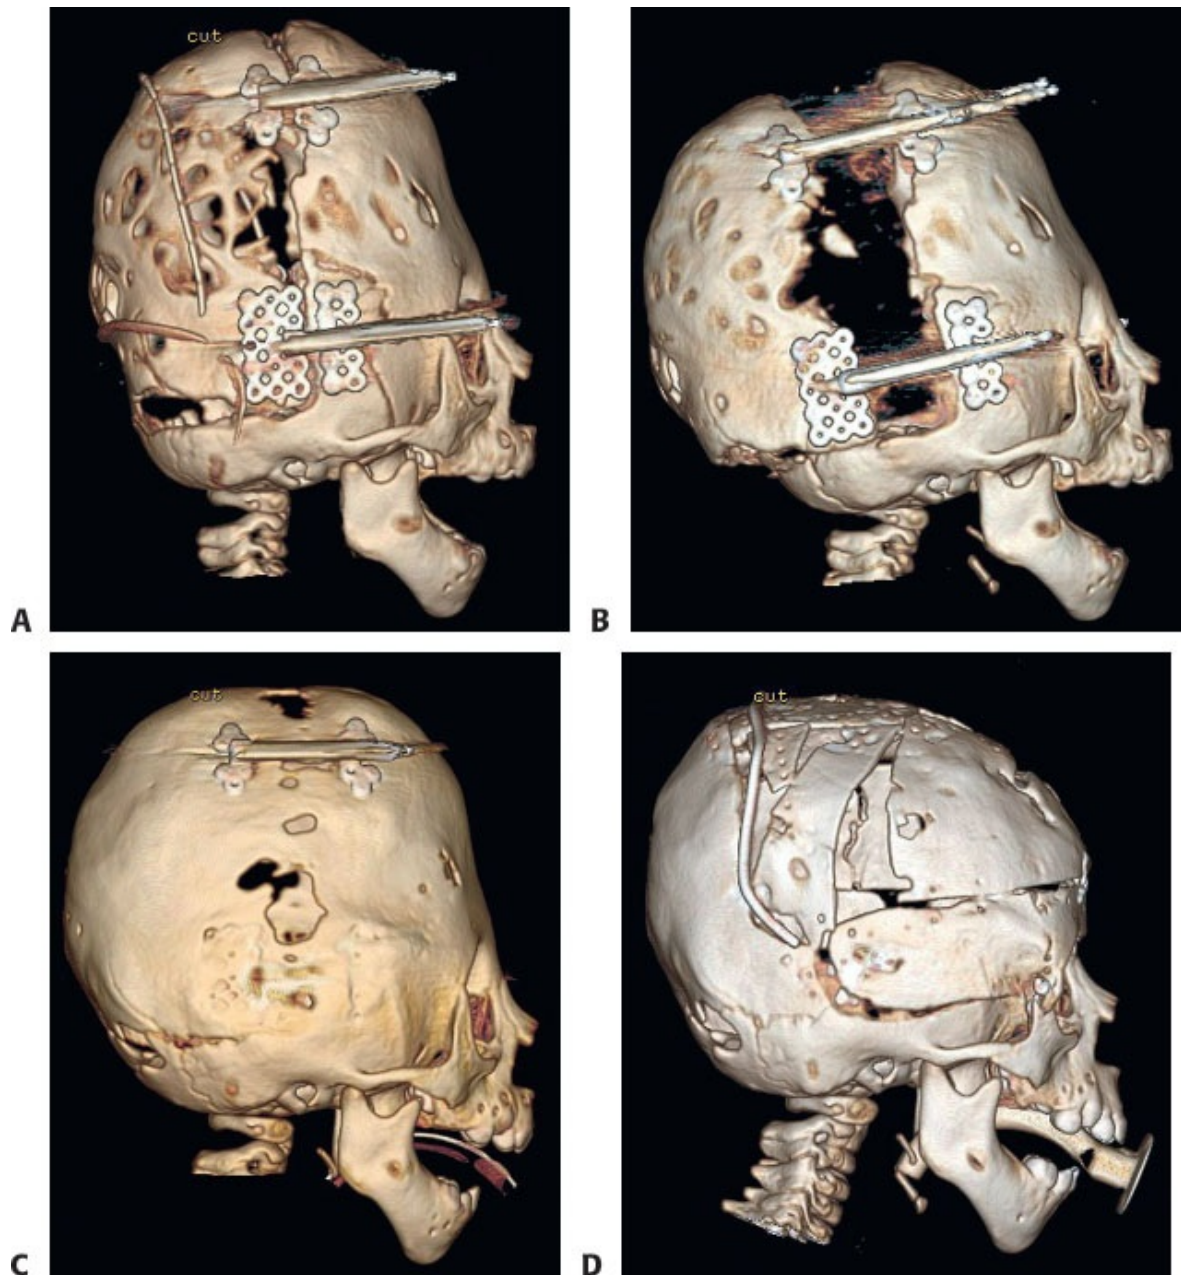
• CT scan images of a 4-month-old patient with pansynostosis and turribrachycephaly undergoing staged posterior and anterior cranial vault expansion. A. Prior to posterior vault distraction, the circumferential posterior osteotomy is bridged by paired parallel internal distraction devices. Note the preoperative posterior calvarial thumbprinting. B. At the end of activation at a rate of 1 mm/day, the posterior vault has
